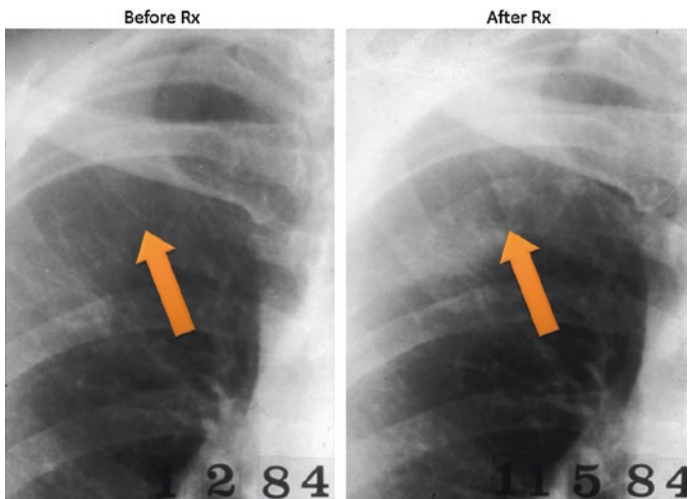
Chest X-ray of patient treated with formestane. Rib metastatic lesion: re-ossification after treatment
